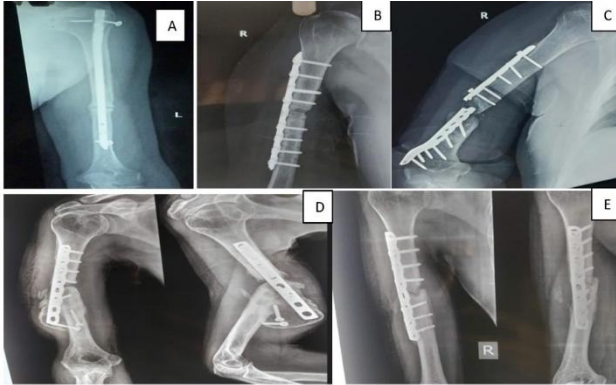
X-rays depicting different non-union cases: (A) X-ray depicting non-union in nail at 9 months, (B) X-ray showing no signs of union at 6 months, (C) broken implant after 5 months due to non-union, (D) broken implant after 4 months after gap non-union and (E) non-union at 6 months after reoperation with bone grafting and compression planting.
